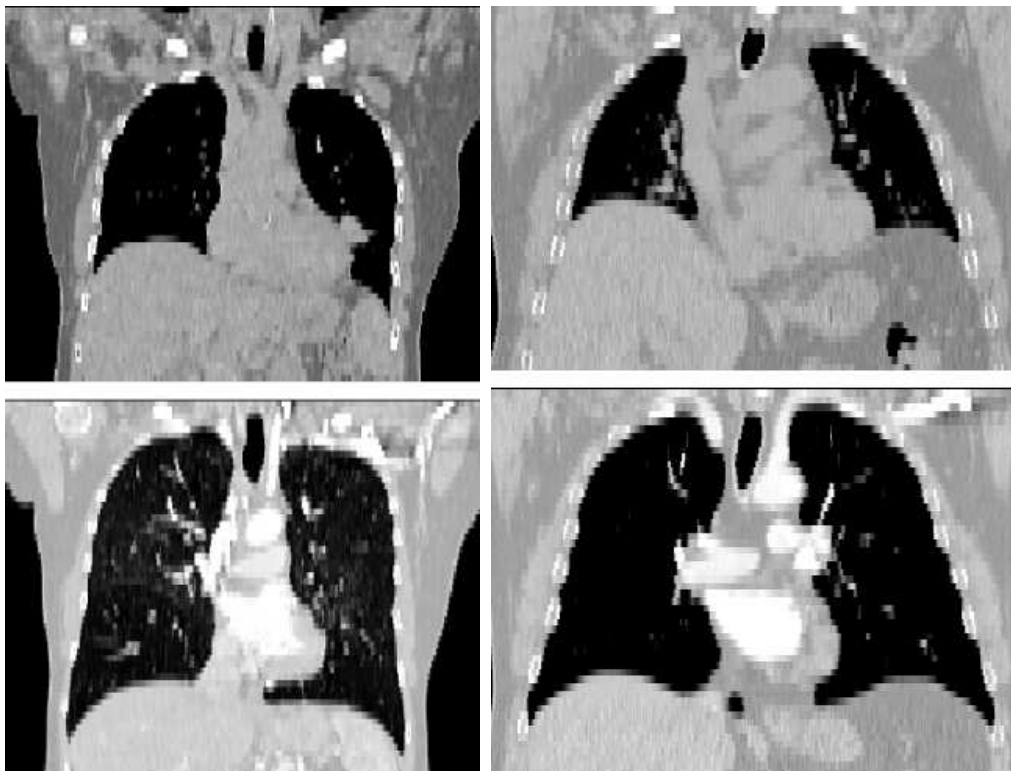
Examples of deformations suffered by the lungs through the respiratory cycle. Top images show CT scans acquired at normal respiration while bottom images show those ones performed in a single breath-hold. Left: patient 1; right: patient 2.
